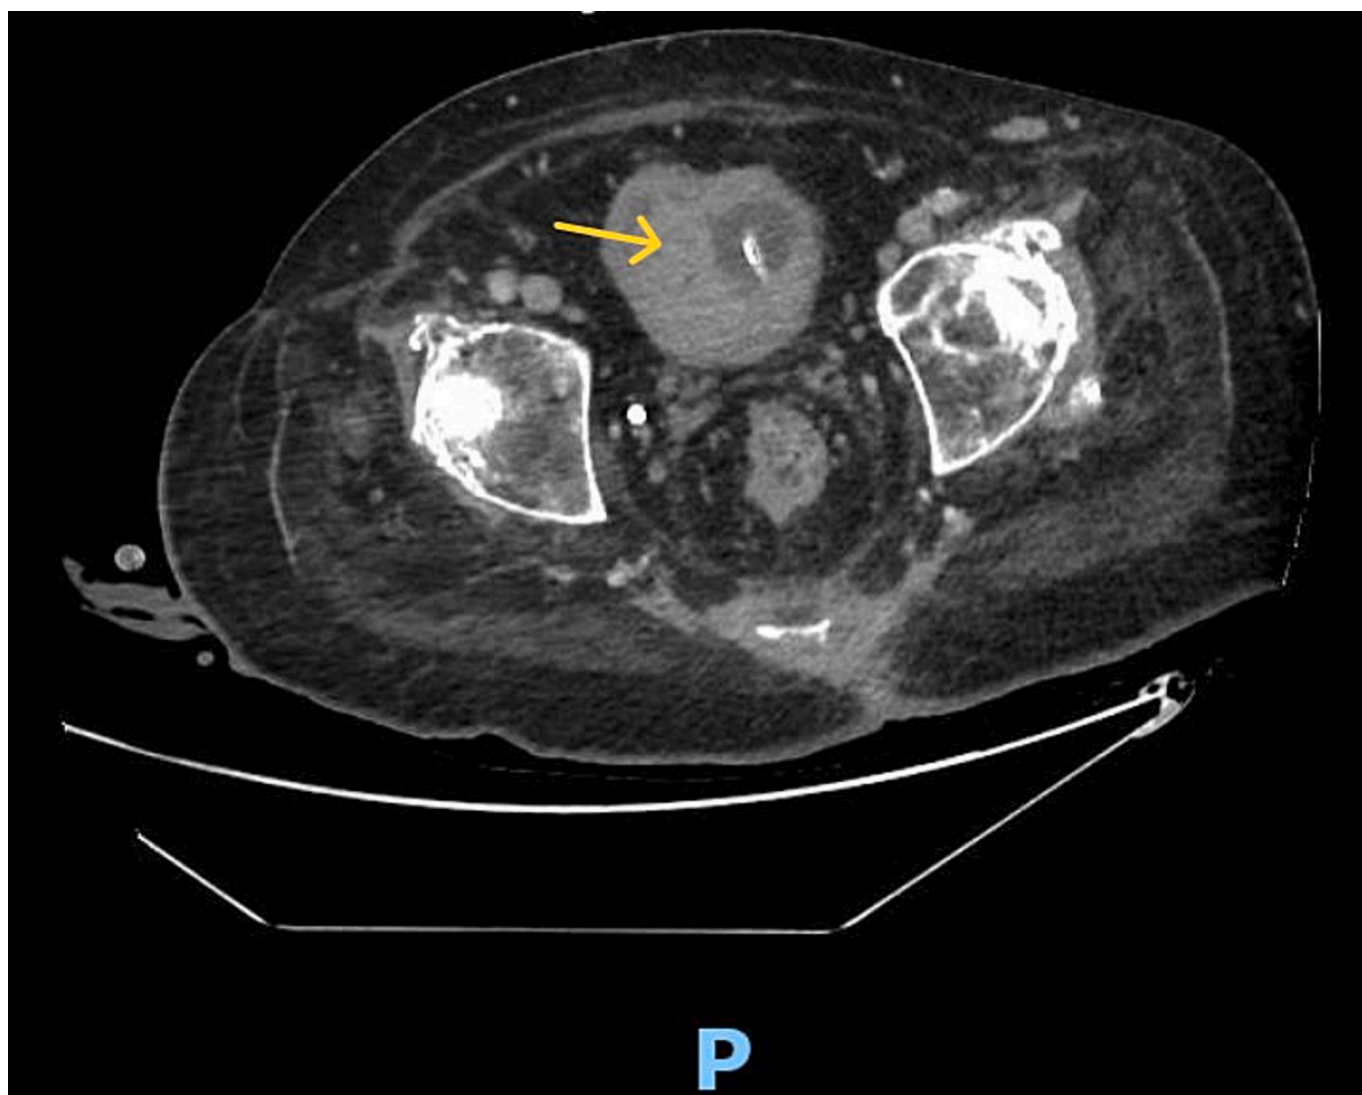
CT of pelvis (axial view) performed eight days after the first CT shown in Figs. 1, 2 and 3 shows blood clot within the urinary bladder (arrow). Balloon of Foley catheter is seen inside the bladder.
